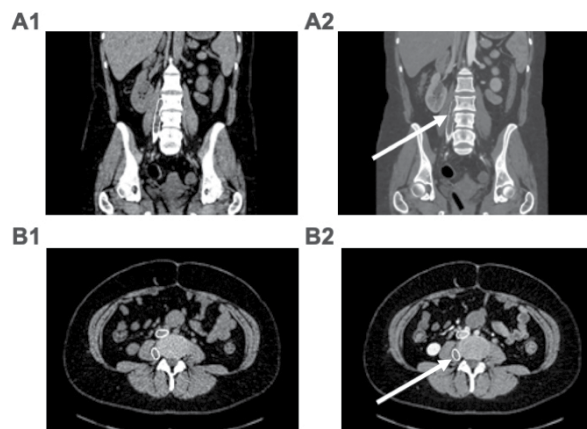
Computed tomography of the abdomen and pelvis with and without contrast shows the variant course of right iliac vein between the psoas and spine and complete occlusion of the kissing stent (arrows).
